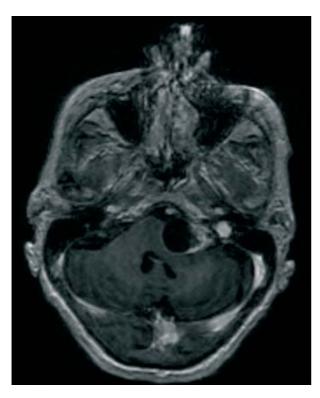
MRI showing an extra-axial lesion in the left cerebellopontine angle, with a mass effect on the brainstem and the fourth ventricle. A solid enhancing portion extended in the internal acoustic meatus and a medial cystic portion (2.5 cm diameter) compressed and displaced the brainstem.
